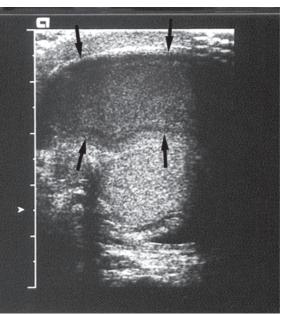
I Ultrasound of the right scrotum showing echogenic fluid (arrows) in the scrotal sac.
